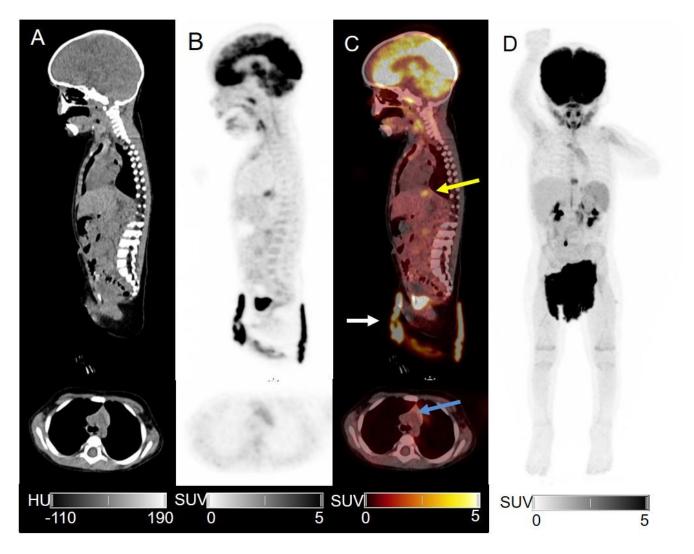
CT, PET and fused PET/CT in sagittal, axial and MIP reconstructions (A-D) after 120 sec PET acquisition. Color scale from 0-5 SUV. No pathological uptake, but reactive accumulation in the distal part of esophagus (yellow arrow), physiological thymic uptake (blue arrow) and accumulated urinary activity in the diaper (white arrow).
